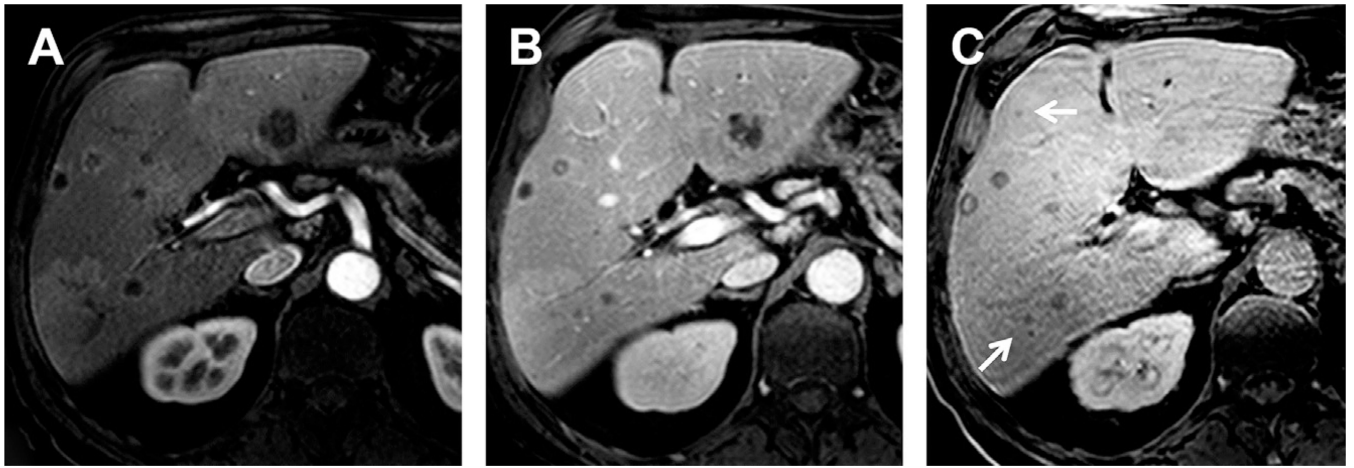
Pancreatic cancer liver metastasis with Gd-BOPTA. (A, B) DCE-MR imaging during arterial and venous phases demonstrates multiple nodules with ring enhancement. (C) The HB phase permits the depiction of more millimetric metastases (*arrows*), which appear as hypointense nodules.
